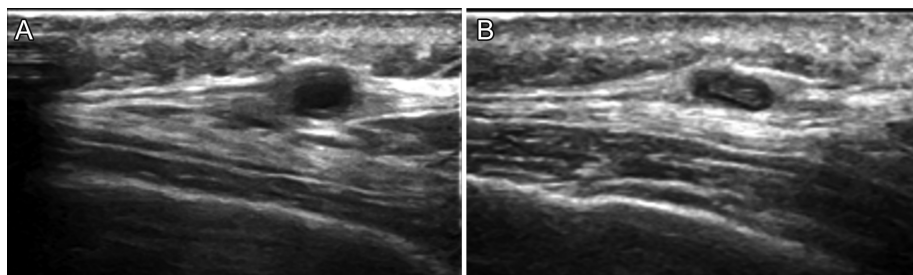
Temporal artery ultrasound in a patient with giant cell arteritis, cranial subset. Pathological characteristics by US in GCA: wall thickening (A), non-compressible arteries (B).
